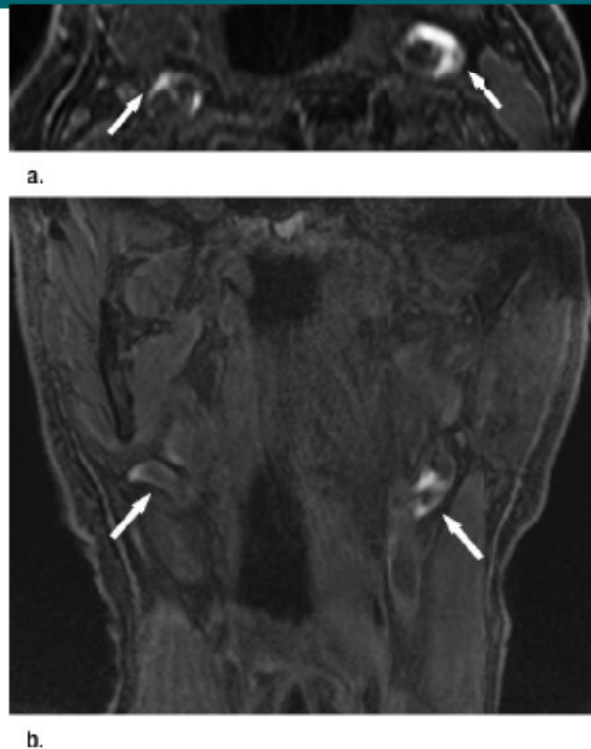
(a) Axial and (b) coronal MR images of a 77-year-old man with bilateral carotid artery vessel wall hyperintensities signifying MR-depicted IPH (arrows).
